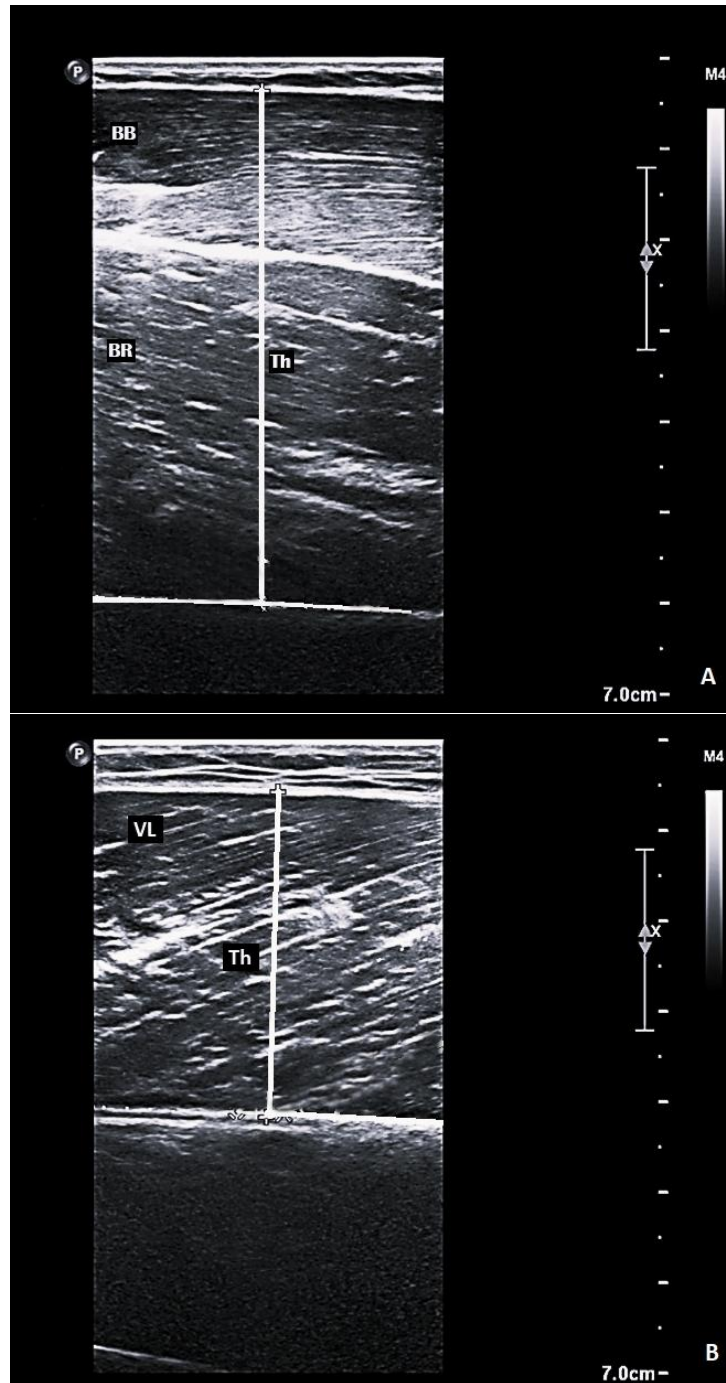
Ultrasonography images depicting measurement results for muscle thickness in EF (A) and VL (B) muscles.
